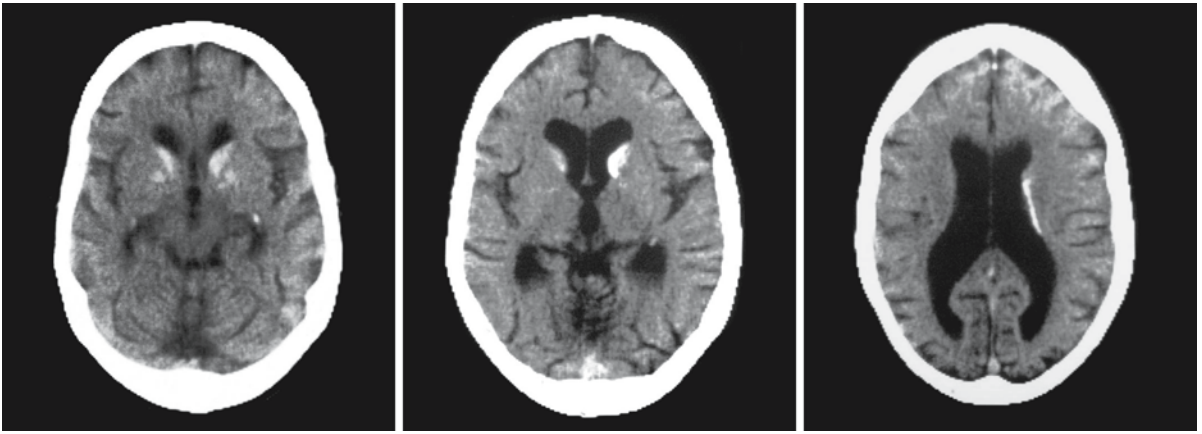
Male patient, 29 years old, with KSS. The CT scan reveals calcium in the head and tail of the caudate nucleus and in the globus pallidus. There is some generalized atrophy
